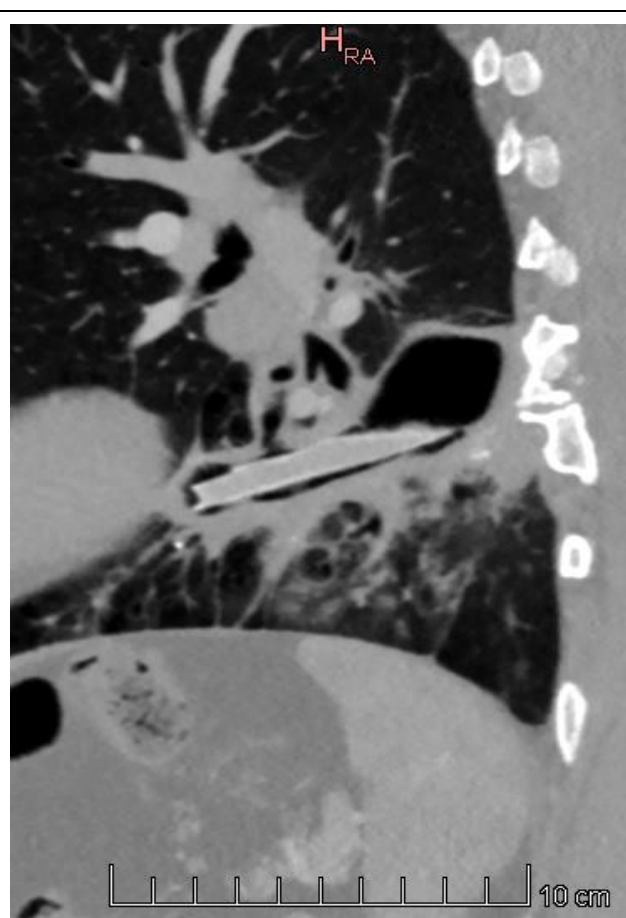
Sagittal CT reconstruction confirming intrapulmonary foreign bodies within the left lower lobe.
